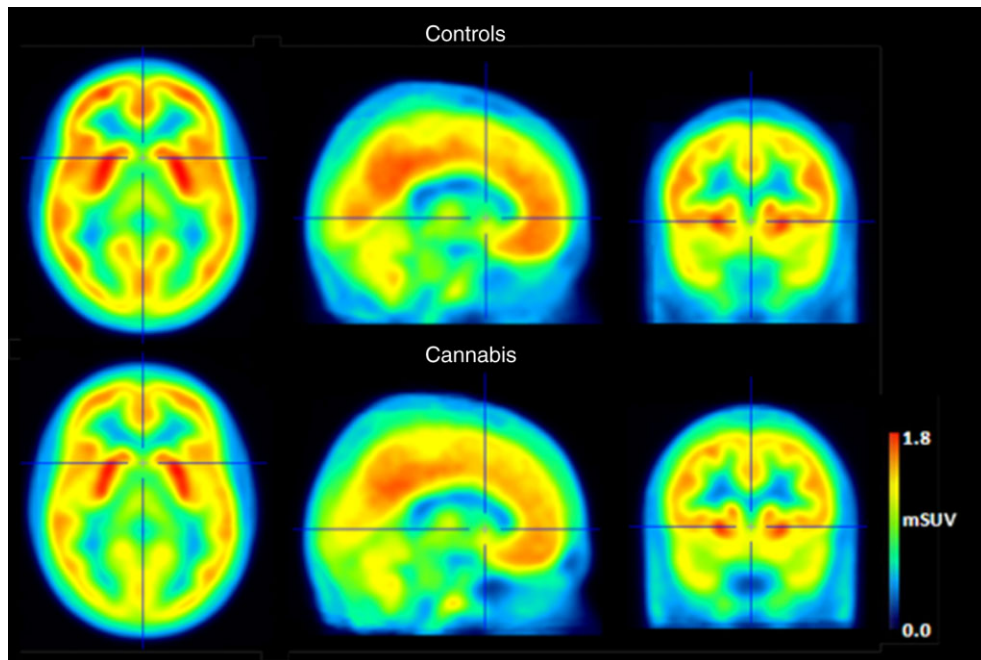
Average modified standardized uptake value (mSUV) parametric images of global CB₁ receptor availability for controls and cannabis users. The colour bar indicates [¹⁸F]MK-9470 binding (mSUV) index
